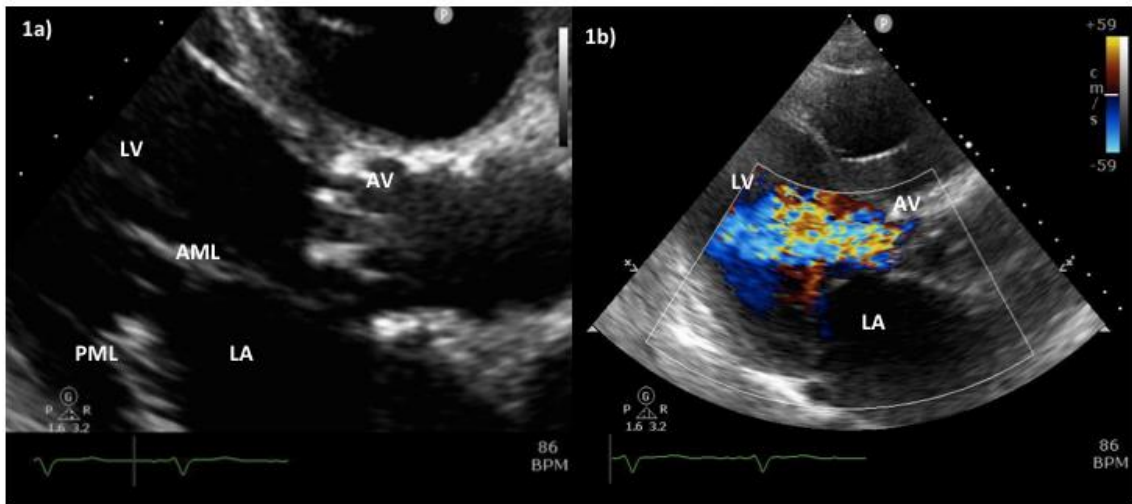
Transthoracic echocardiogram showing the left atrium (LA), anterior mitral leaflet (AML), posterior mitral leaflet (PML), left ventricle (LV) and aortic valve (AV). a Shows abnormal AV. b Colour flow mapping shows turbulent flow indicative of aortic regurgitation.
